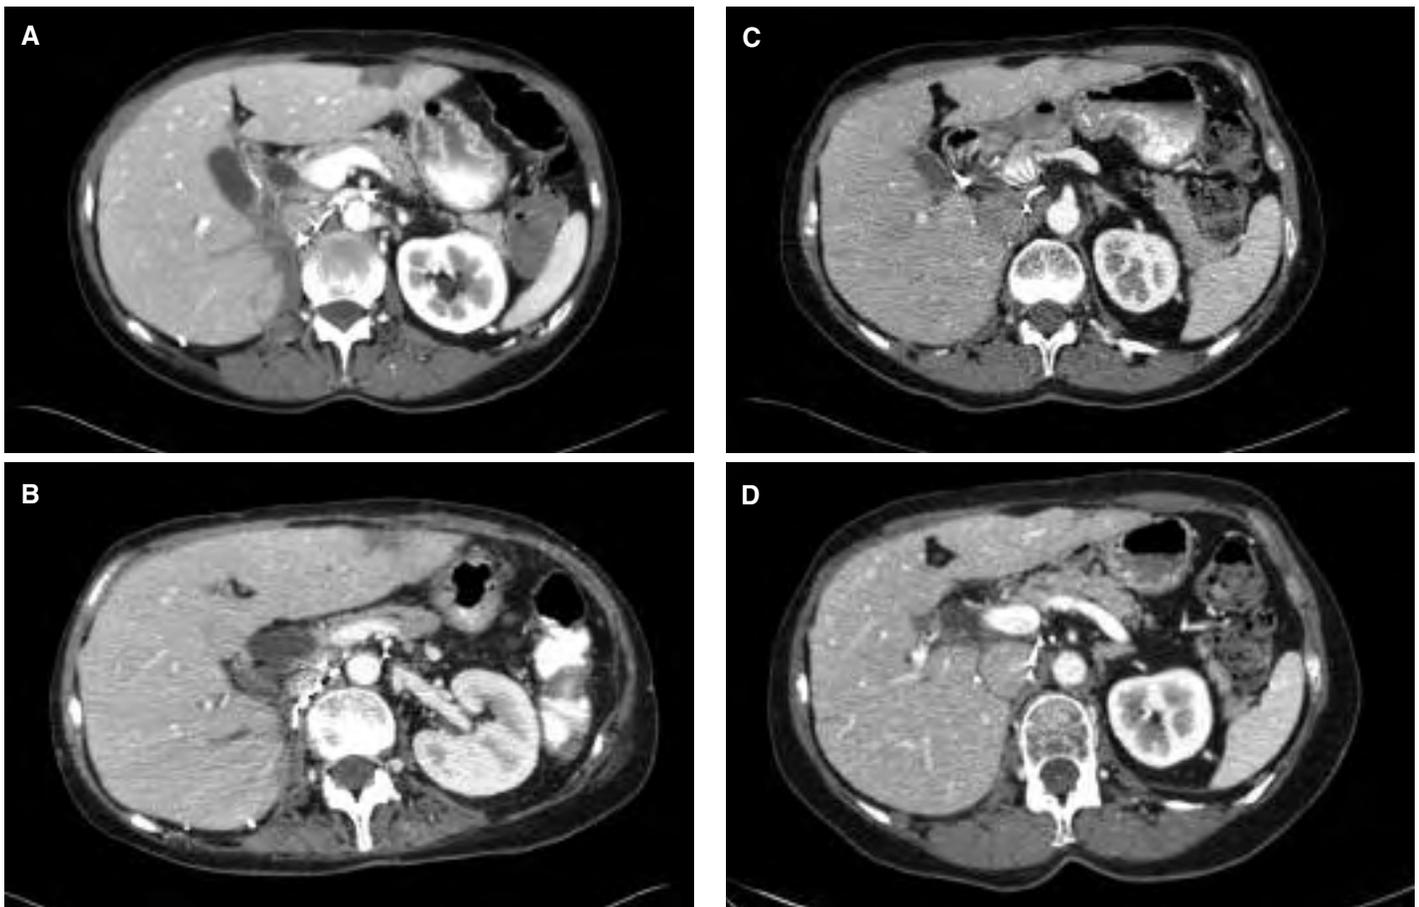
CASE 1. Computerized tomography of the upper abdomen with intravenous contrast taken before (A), during (B) and after (C) high dose interleukin-2 therapy and at 7 year follow-up in 2011 (D). The patient's left lobe of liver metastasis decreased in size and contrast enhancement progressively during HD IL-2 to leave a low density defect on CT scan.
